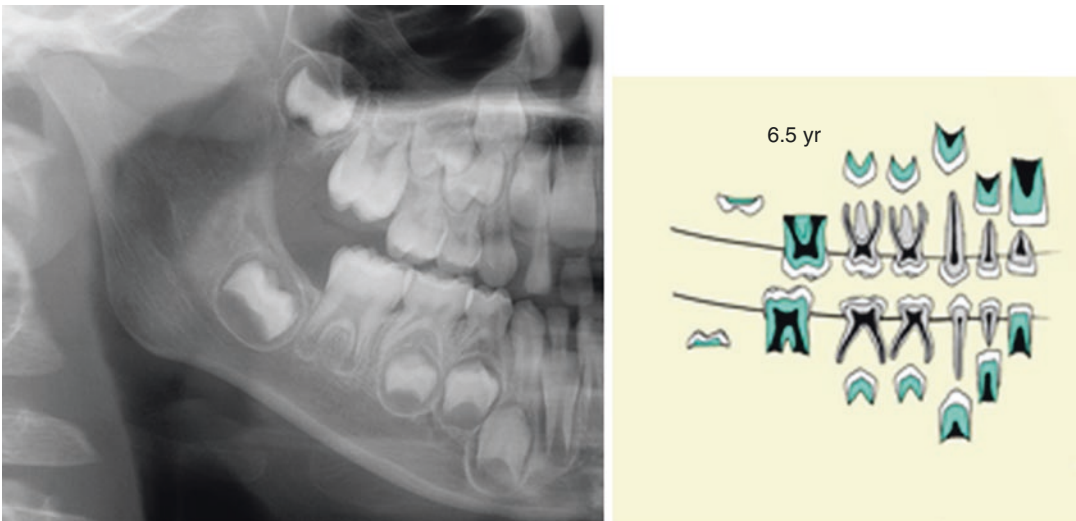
The radiographic image of a developing dentition is associated to one of the schemes in the atlas
